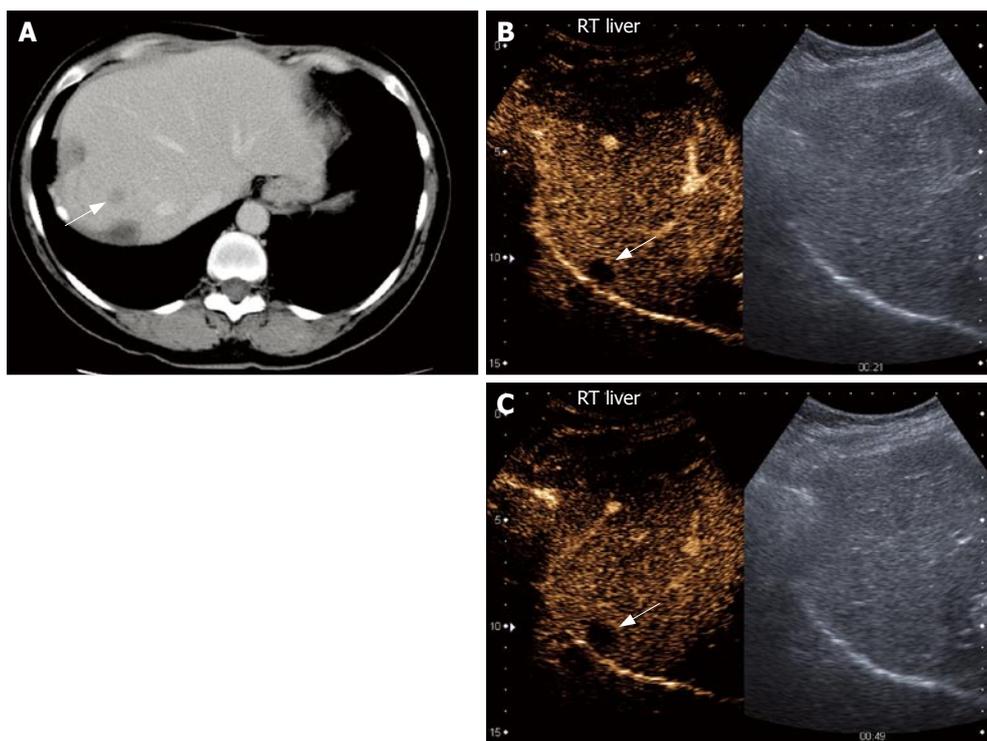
Liver metastasis in a patient with known metastatic colon carcinoma. The patient previously had liver resection and radiofrequency ablation. Contrast-enhanced CT scan image (A) and split-screen display images of a contrast-enhanced US scan using a low MI technique (B and C). On CT, a 1 cm lesion is seen in segment 8 (arrow, A). The lesion was not visualized on gray-scale US. After injection of microbubbles, a 1 cm hypoechoic rounded lesion is seen as a defect in all the phases of enhancement (arrow, B and C). These findings are suspicious for a metastatic deposit.
